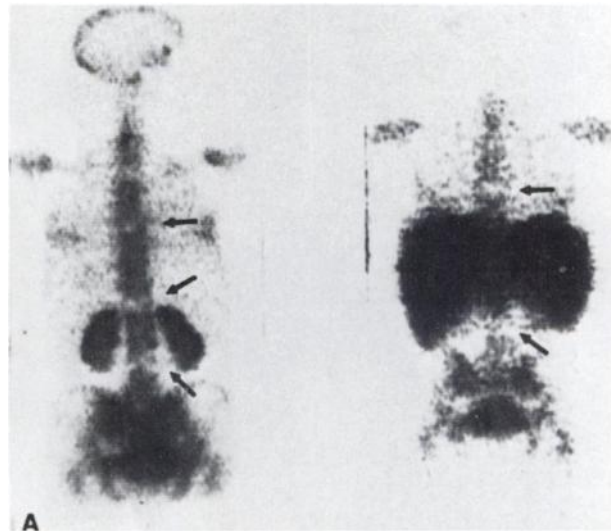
(A) Photon-deficient foci (arrows) in spine, on bone and bone marrow images (Patient 1). (B) Photoscan closeup of spine image in same patient (Patient 1). (C) Negative radiograph of lumbar spine (Patient 1).
